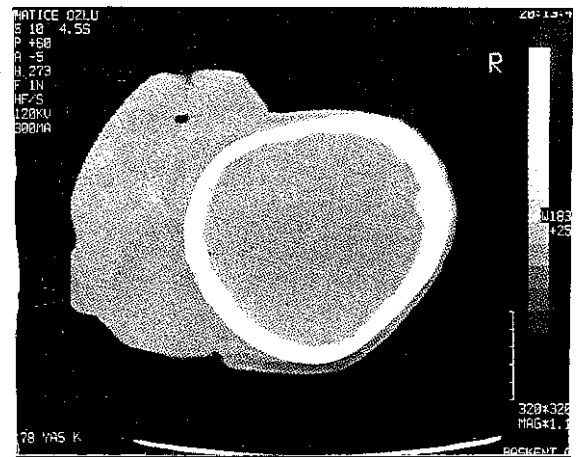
CT of the cranium showing the huge tumor with no intracranial spreading.
